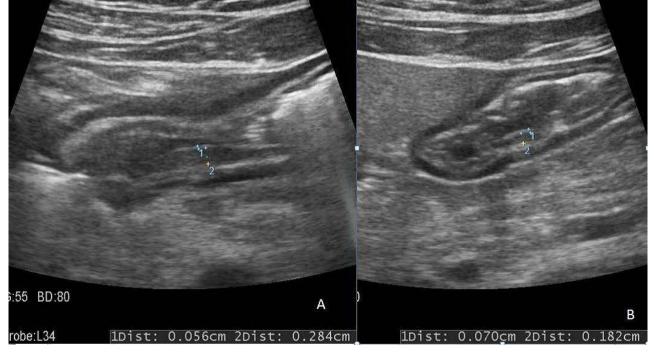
Ultrasound with the Convex Probe showing thickening of Layer 2 of Stomach in Mild Acute Gastritis
